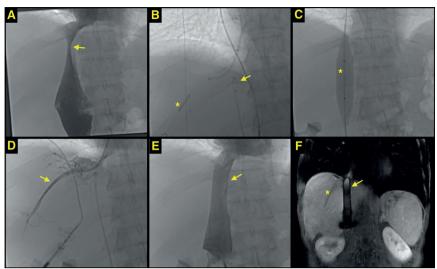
A. Angiography showed IVC stenosis (arrow). B. Hepatic vein baloon dilatation (asterisk) and pigtail catheter in IVC (arrow). C. IVC balloon dilatation (asterisk). D. Hepatic vein flow after angioplasty (arrow). E. IVC flow after stent implantation (arrow). F. MRI showed patent hepatic vein flow (asterisk) and IVC stent (arrow).
